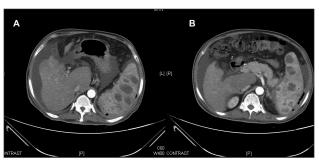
Abdominal computed tomography scans (A, B) showing multiple splenic abscesses. Note markedly irregular liver outline and ascites suggestive of chronic liver disease.
